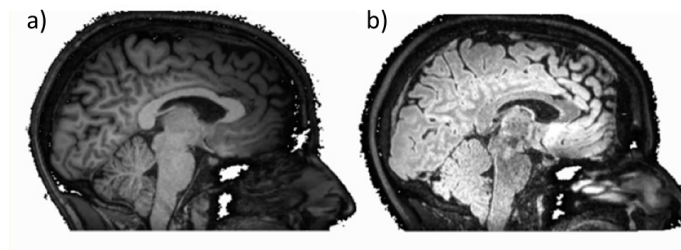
Sagittal view of an a) MPRAGE and b) T₂ FLAIR
